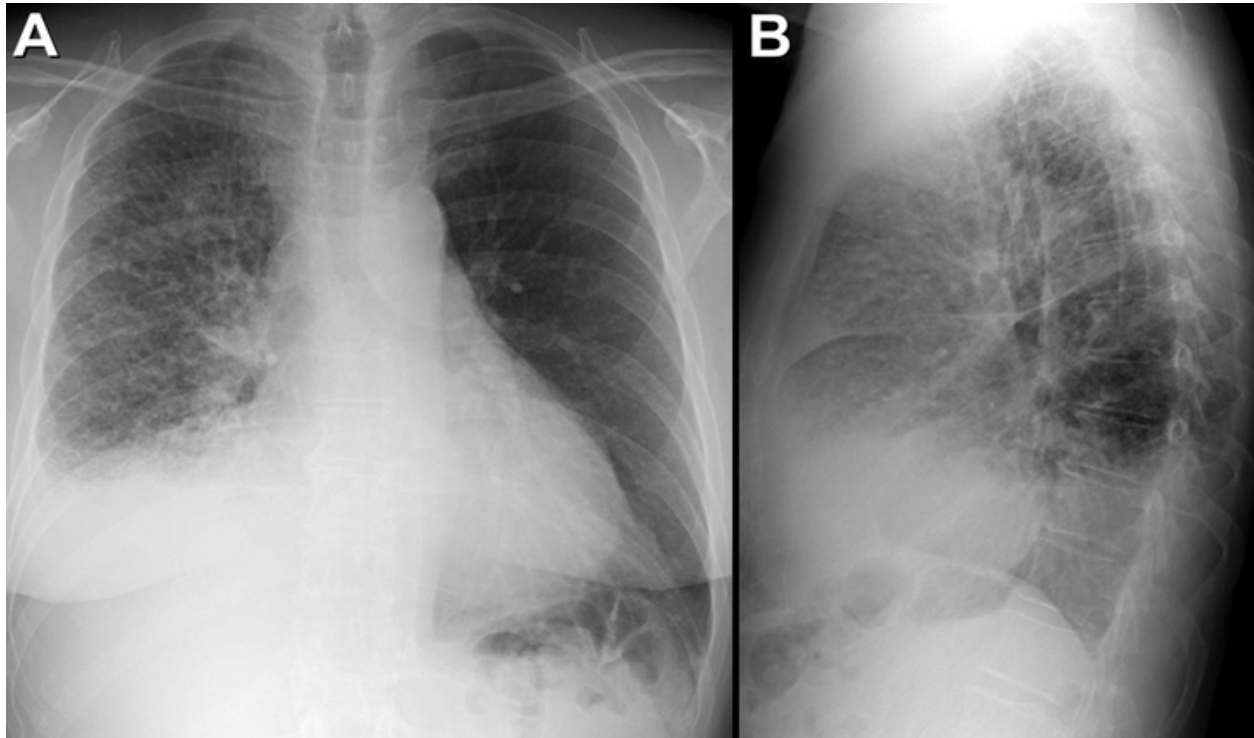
Frontal (panel A) and lateral (panel B) chest radiograph.
